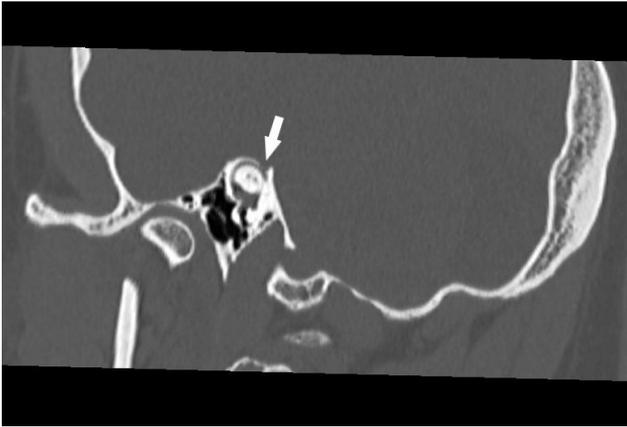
Reformatted CT image of the right SSC on the plane of Poschl shows the discontinuity of the bone over the right membranous SSC, at the level of the groove for the superior petrosal sinus (arrow).
